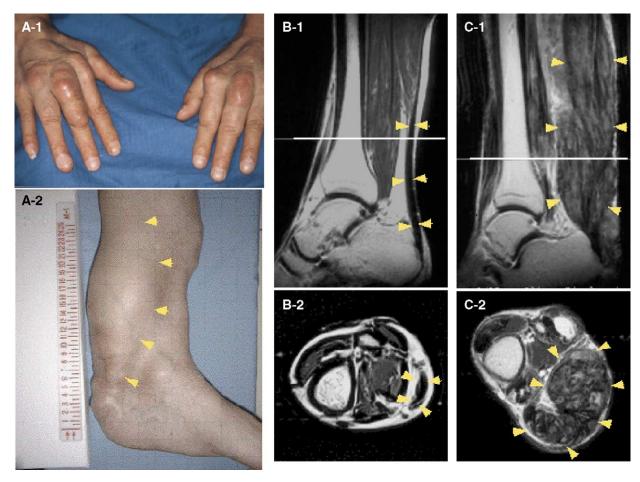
Massive tendon xanthomatosis on the proband's extremities. A, Massive xanthomas observed on the proband's hands (A-1) and his left lower limb (A-2). B, C, Magnetic resonance images of the lower limb of healthy control subject (B-1 and B-2) and the proband (C-1 and C-2). B-1 and C-1 show longitudinal images. B-2 and C-2 show cross-sectional images at the level of white bars. Arrowheads in each figure show the margin of Achilles tendon.
